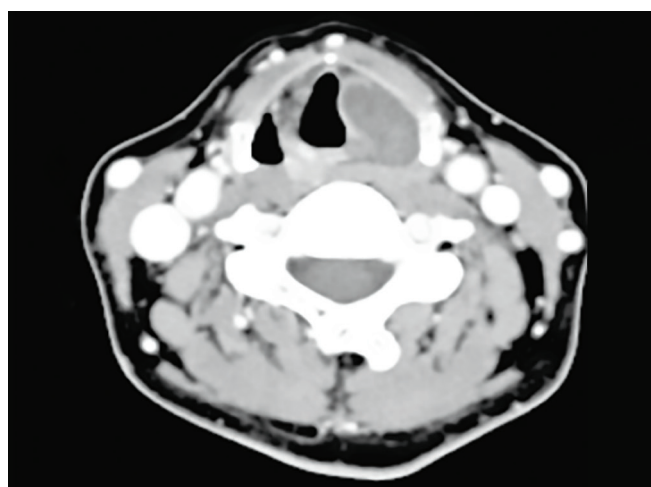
Computed tomography scan showing a 22 × 23 × 28 mm well-defined submucosal mass in the left supraglottic area
